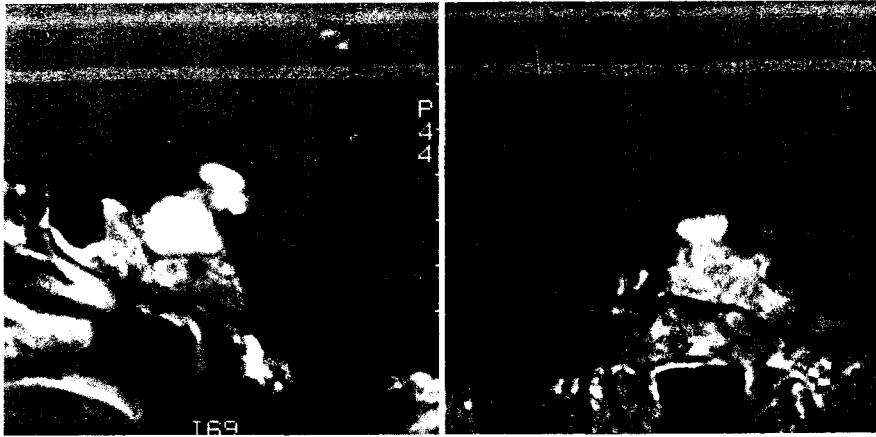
Patient 1. Left, sagittal MRI scan with Gd-GTPA enhancement demonstrating the lesion filling the pituitary fossa, with significant suprasellar extension. Right, coronal MRI scan with Gd-GTPA showing the pituitary fossa filled with tumor with extension laterally to encase the carotid artery and inferiorly eroding into the sphenoid bone.
